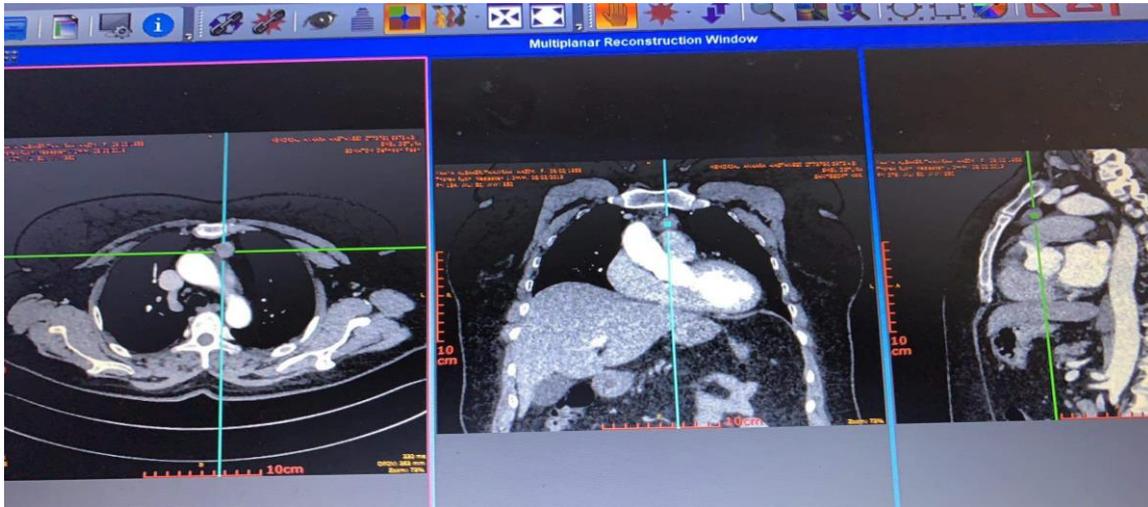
CT scan showing the adenoma located in the anterior mediastinum near the manubrium sterni
